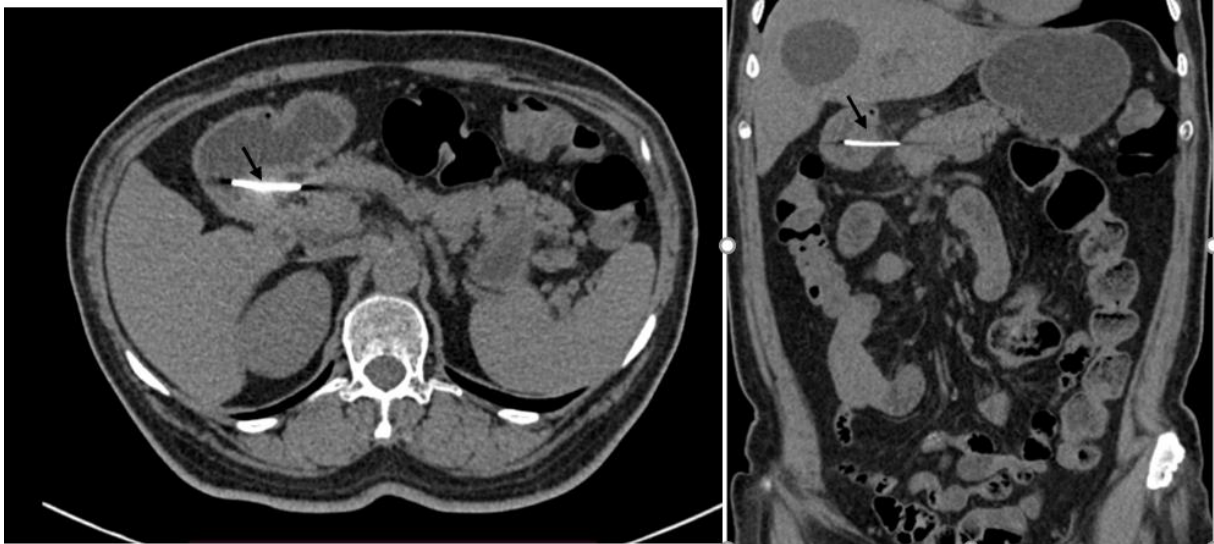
Computed tomography abdomen shows the hairpin (black arrow) in gastric wall with intimate contact of the pancreas head
